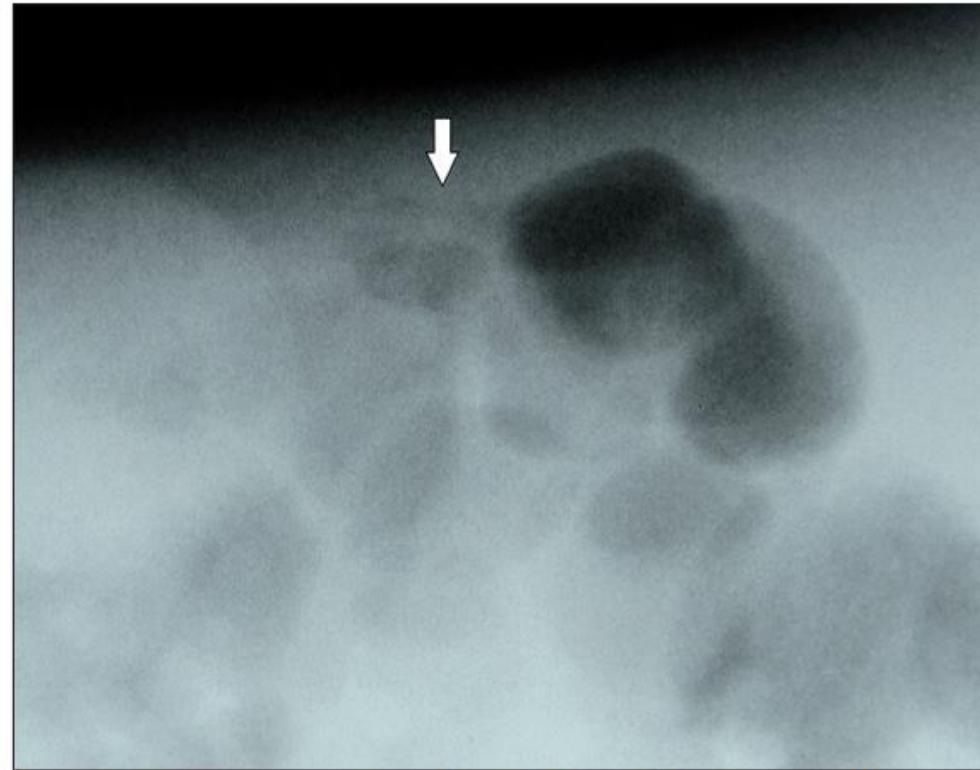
Plain x-ray performed in left lateral decubitus position: tiny air bubbles within intestinal wall (arrow).
